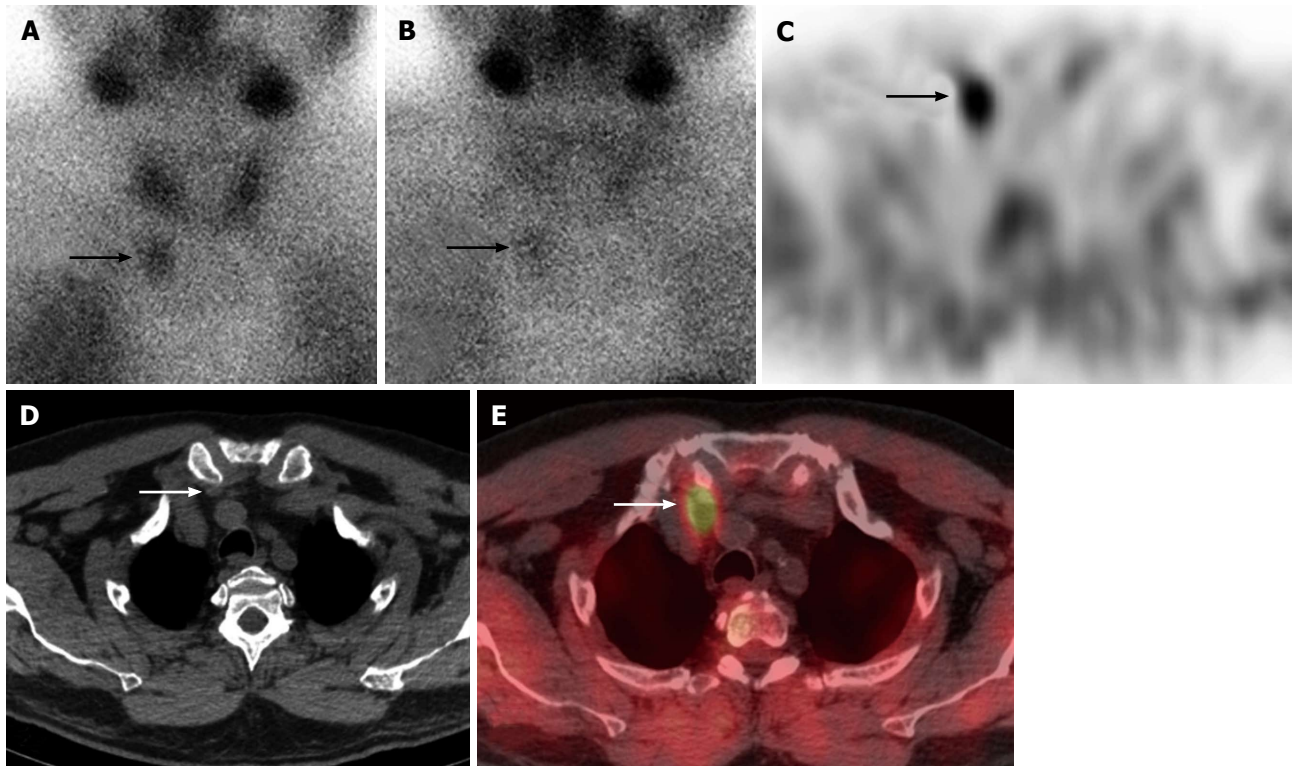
Right inferior parathyroid adenoma in a 60-year-old man. ^{99m}Tc -sestamibi parathyroid scan anterior early 20 min (A) and delayed 2 h planar images (B) show focal radiotracer uptake and retention at the junction of the right lower neck/superior mediastinum (arrows). Axial SPECT, CT and SPECT/CT (C-E) imaging localizes this activity to a soft tissue abnormality in the right lower neck posterior to the sternoclavicular joint (arrows), consistent with ectopic inferior parathyroid adenoma in the lower neck. This was surgically removed via a lower neck incision approach. SPECT: Single photon emission computed tomography; CT: Computed tomography.
